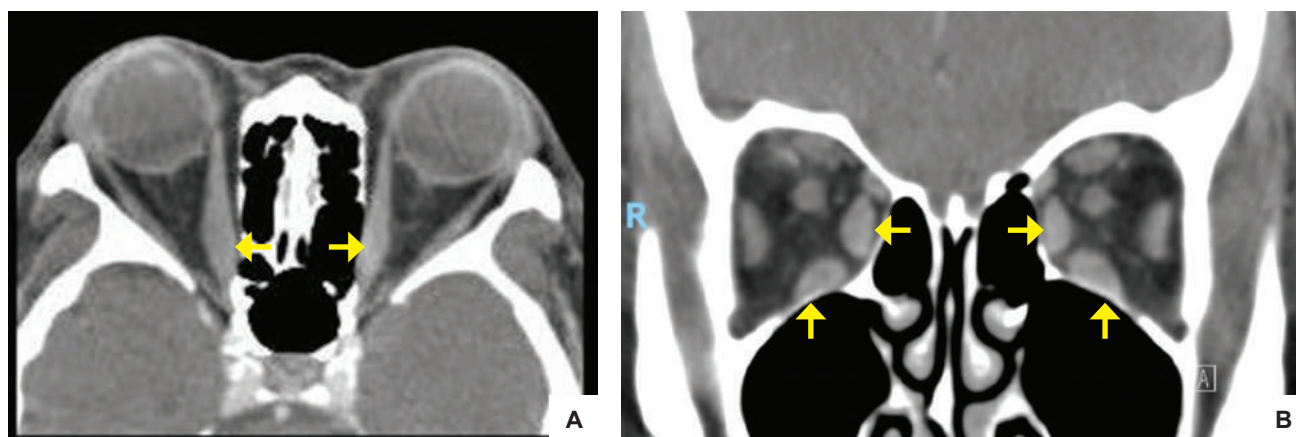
CT scan of the orbits at presentation of GO with (A) axial and (B) coronal views (2017). Bilateral proptosis, bulky inferior and medial rectus muscles (arrows) with medial deviation of the right eye globe. Optic nerves are stretched without compression.
